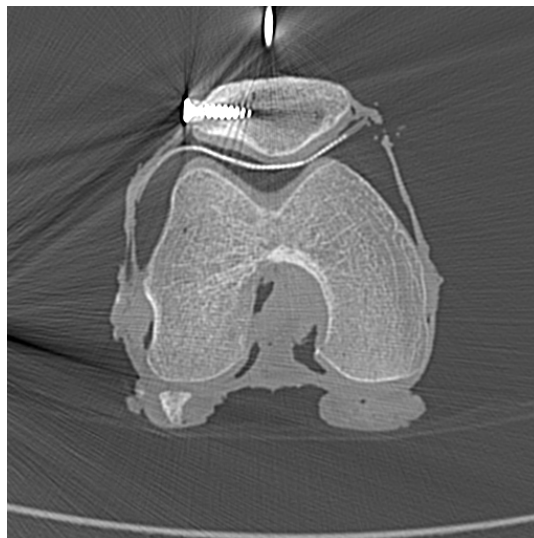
CT-Image of a left knee joint with artifacts due to clips and screws of metal, stored in a dicom file.
